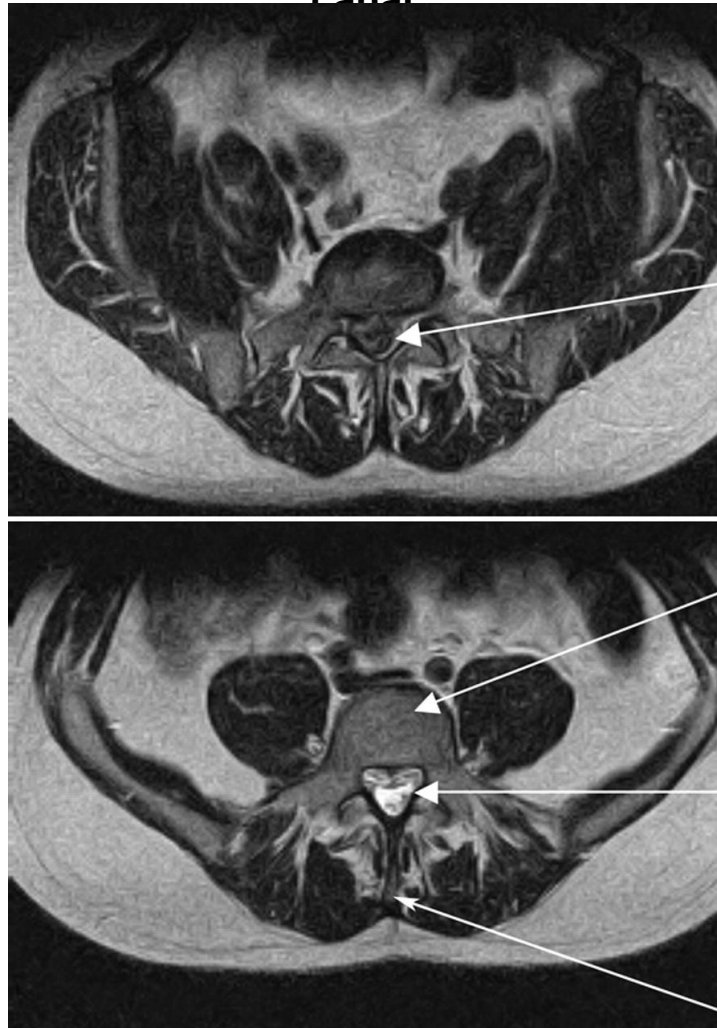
Left: MRI scan showing compression of the cauda equina (arrow) due to a large posterior disc herniation at L4/5.
